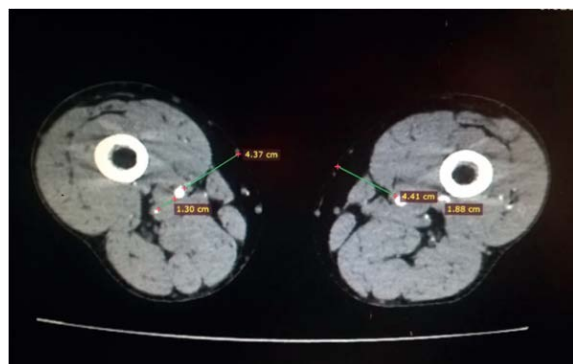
CT angiogram, transverse section at the level of the lower third of the thigh
